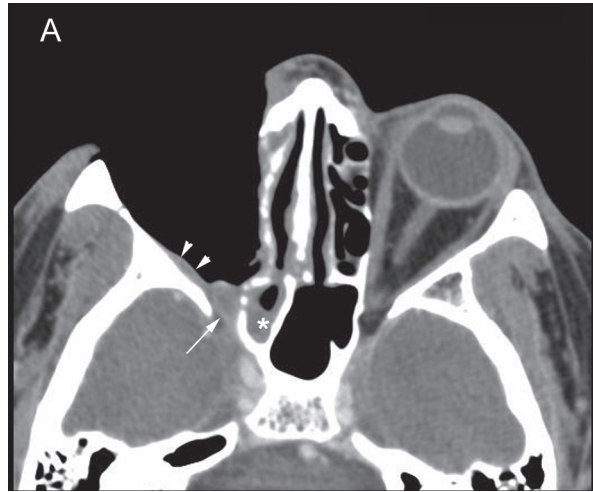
Repeated noncontrast axial computed tomographic (CT) images obtained after enucleation of the right orbit and extensive sinus surgery, and after 6 days of posaconazole therapy.
